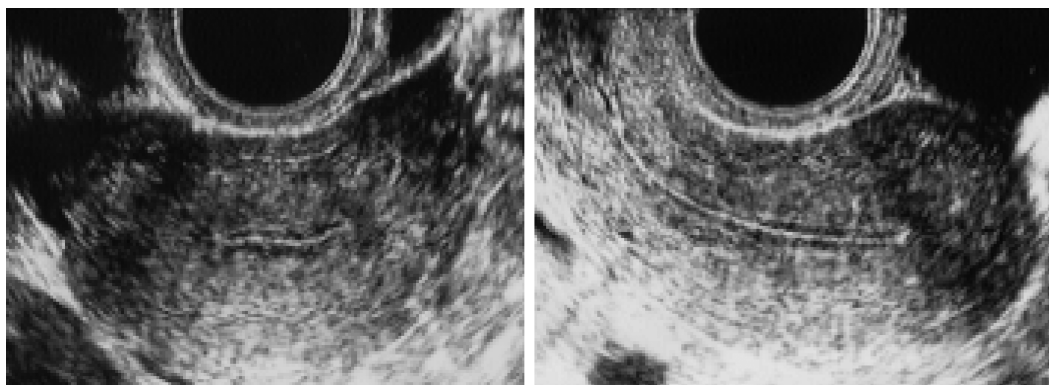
Transvaginal ultrasound scan control two weeks after the combined treatment.
